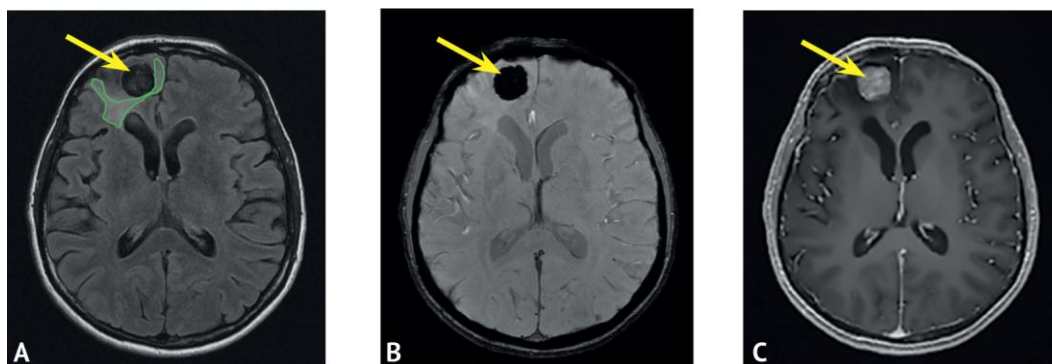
Results of control magnetic resonance imaging performed 33 months after stereotactic radiosurgical treatment: A - axial slices in FLAIR mode; B - axial slices in SWAN mode; C - axial slices in T1 FSPGR mode obtained after intravenous contrast enhancement. There is a change in the tumor contour to a clearer one (arrow), a decrease in the edema of the right frontal lobe (the area of edema is outlined with a green line). With intravenous contrast enhancement, the accumulation of contrast agent in the substance of the right frontal lobe is not detected
